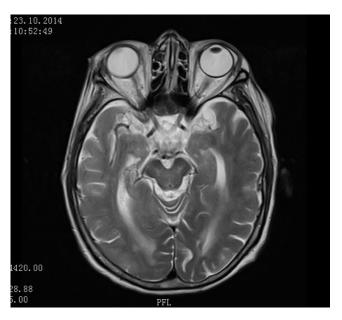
T2 image of control MRI scan presenting regression of intensity changes at first week of the treatment
